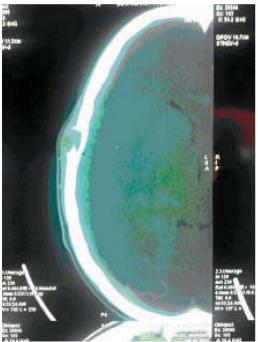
CT head – Axial section showing and osteolytic lesion in the ® high temporal region with interruption of the outer table and intact inner table of the skull.
